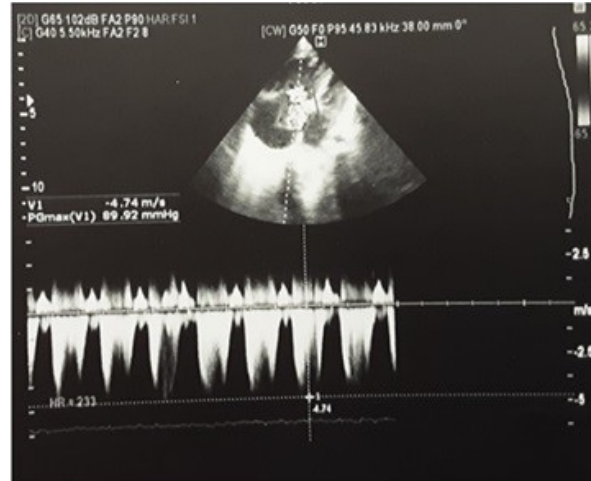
Spectral Doppler echocardiography across the tricuspid valve demonstrating severe tricuspid regurgitation
